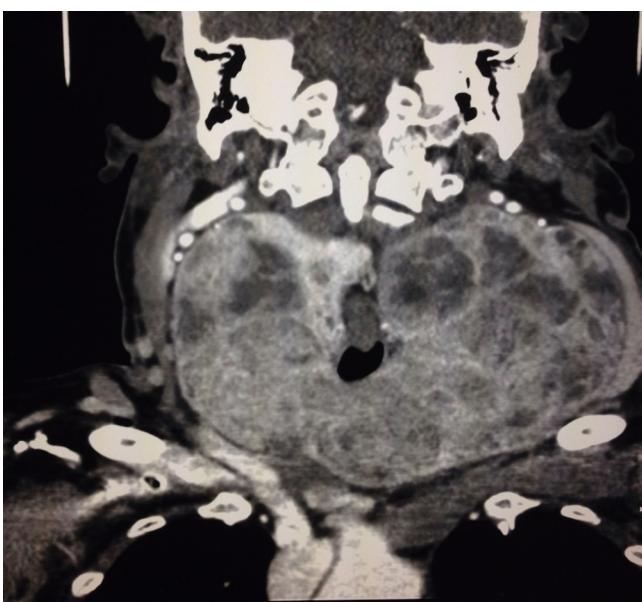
Coronal CT image.
